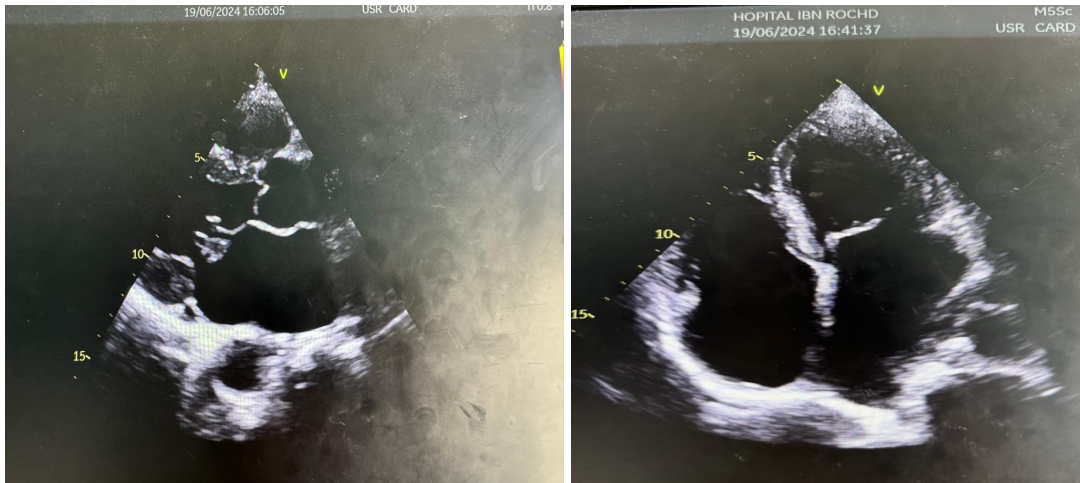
Parasternal Long-Axis and Short-Axis Views Showing Bi-Atrial Dilatation.
